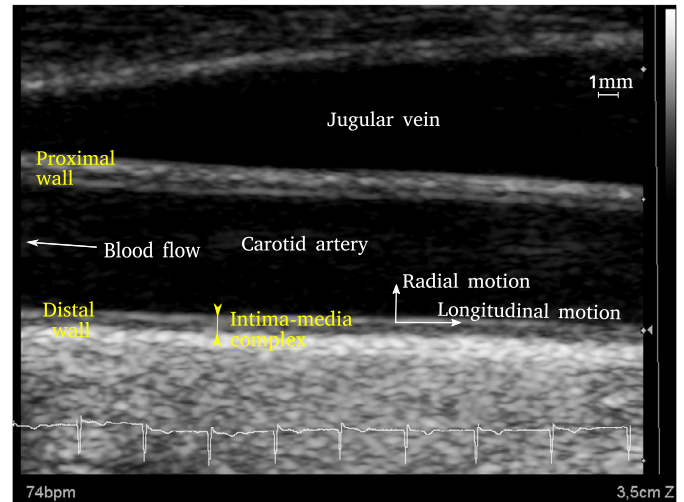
Example of longitudinal ultrasound image of the common-carotid artery.
